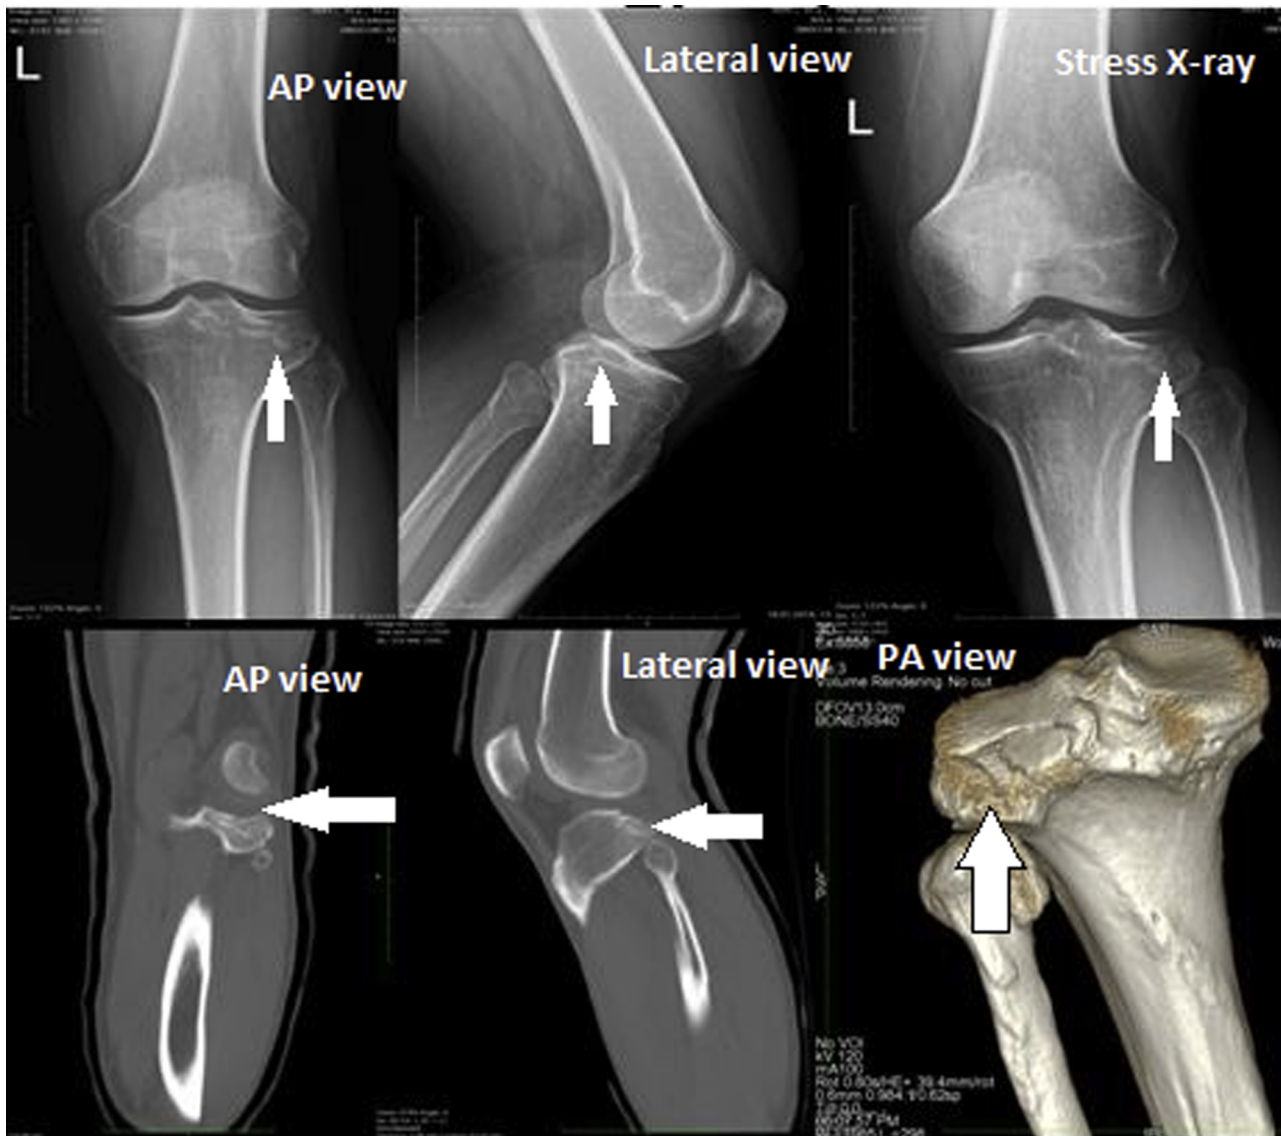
Left knee type III lateral tibial plateau fracture on anteroposterior and lateral radiographs, frontal and sagittal computed tomography scans, and 3-dimensional reconstruction. White arrows present the posterolateral tibial plateau depression. (AP, anteroposterior; L, left; PA, posteroanterior.)
